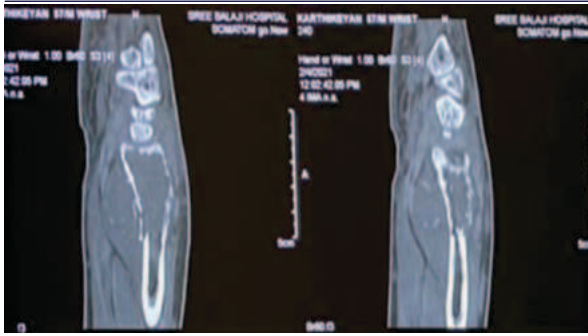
CT SCAN Shows Breach and destruction of cortex.
